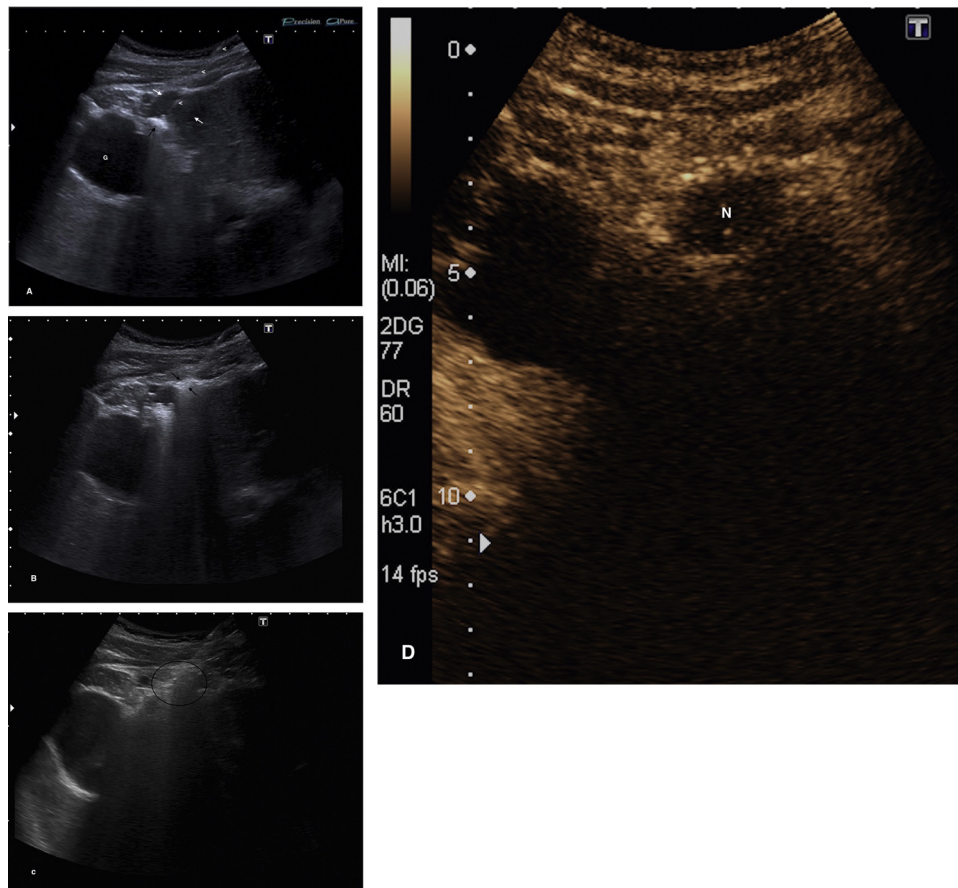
Direct-puncture thermal ablation technique in a 25 mm subcapsular HCC nodule: (A) A cool-tip RF needle (arrowheads) trespasses the target nodule (between white arrows). Ablation starts at the needle tip (black arrow). (G = Gallbladder). (B) After 1 min ablation starts at the proximal part of the exposed tip just at the Glisson's capsule (black arrows). (C) Ablation ends after 12 min: the target nodule is covered by hyperechogenicity due to vaporization gas (encircled area). (D) Contrast-enhanced Ultrasound 5 min after completion of ablation: the treated nodule (N) appears entirely avascular.
